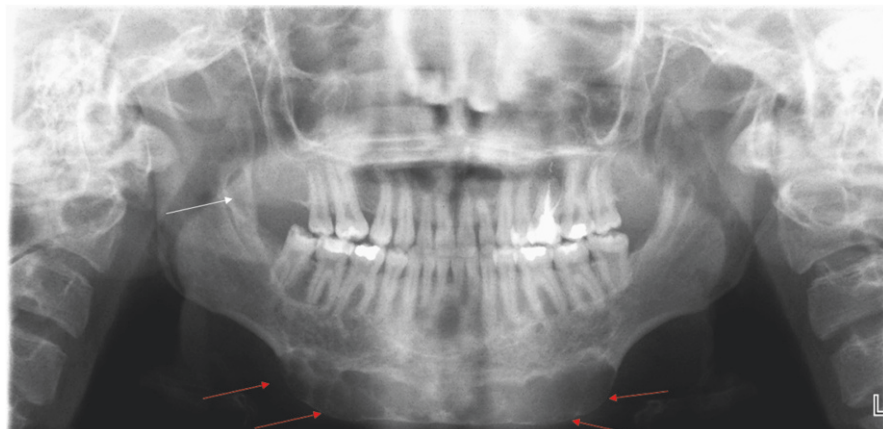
Panoramic radiograph of a 19-year-old female with Noonan multiple giant cell lesion syndrome. An expansile, multilocular radiolucency is seen in the anterior mandible (*red arrows*). A smaller lesion is evident in the right mandibular ascending ramus (*white arrow*) (Radiograph courtesy of Leonard B. Kaban, DMD, MD)
